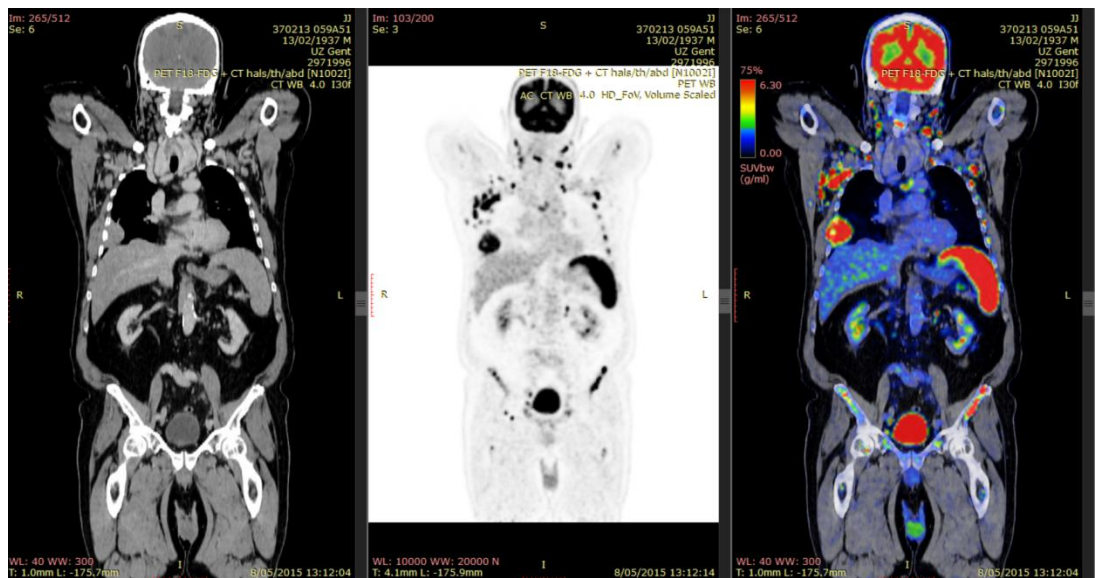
cancer patient undergoing a PET-CT examination. CT-scan (left), PET-scan (middle) and combined scan (right)
